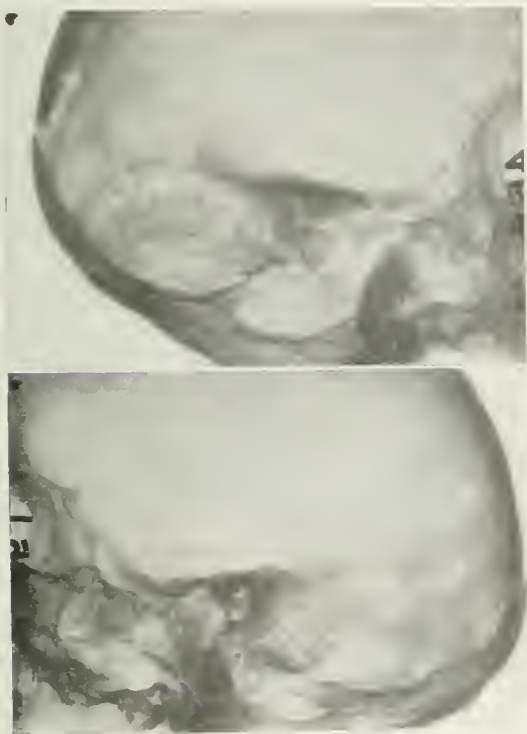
Right Eye Image. Roentgenograms of dried skull. Right side above, left side below, punch marks of both films at the left, numbers and letters reversed.
